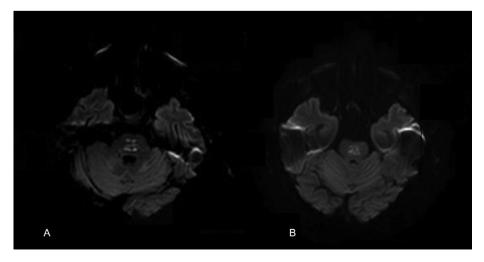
The DWI maps compare two MRI sections performed on day 21 (A) and day 36 (B). A significant reduction in signal restriction is detected on the pons, consequence of a normal evolution of the recent ischemia.
